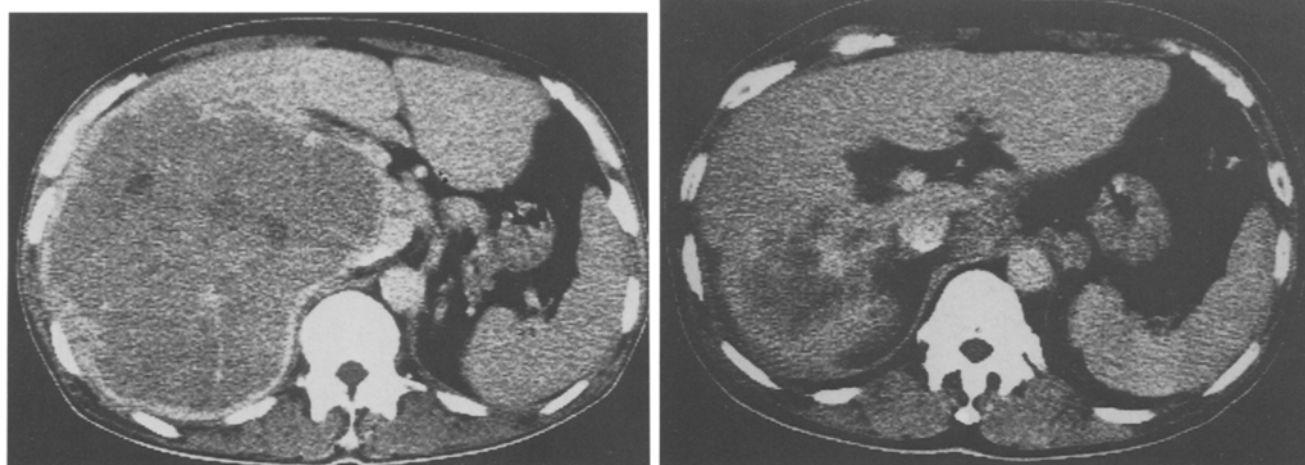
HCC in a 57-year-old man (a) A CT scan reveals a large tumor in the right lobe (b) At 4 months after the onset of therapy, a CT scan shows marked reduction of the tumor
